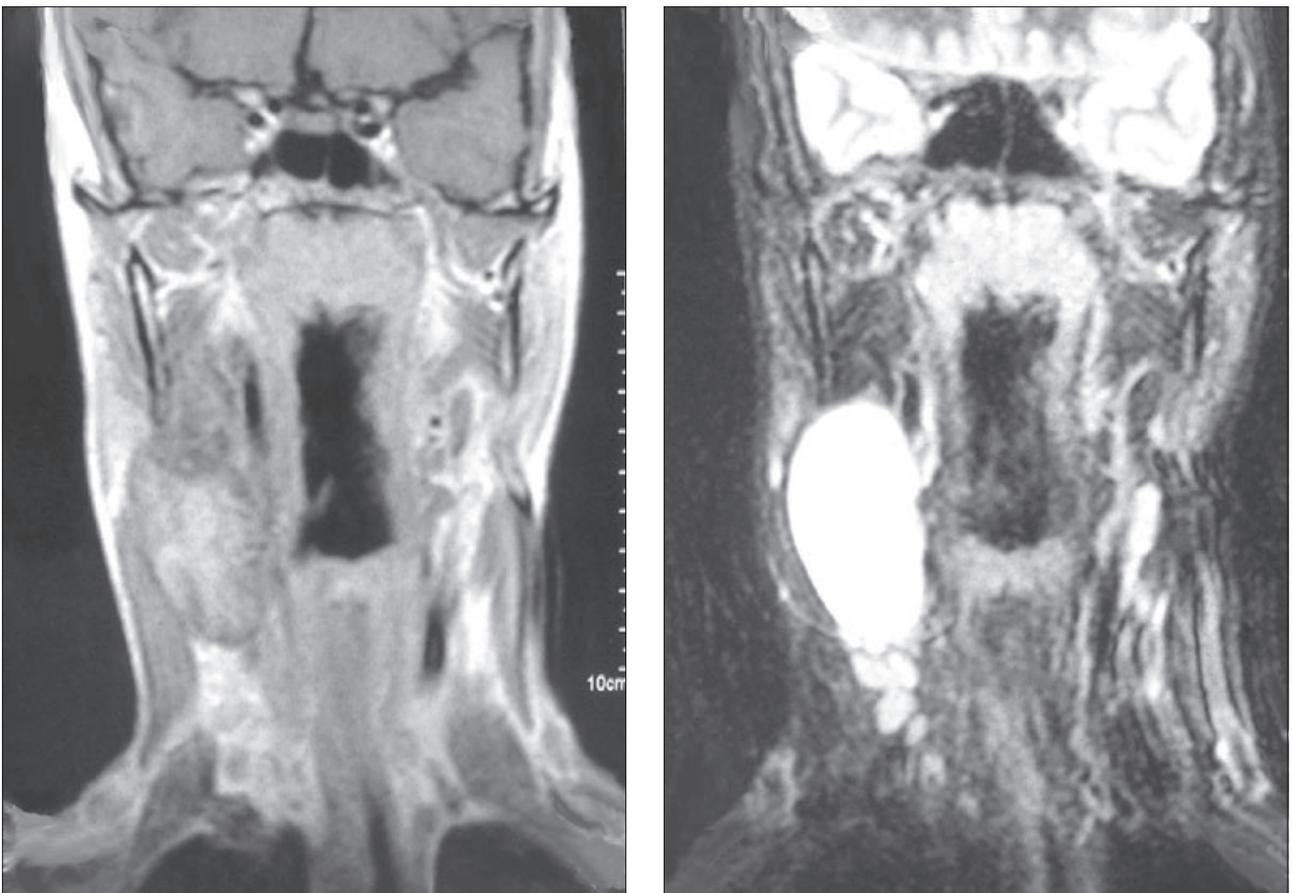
Sagittal view of the patient's MRI scan, showing location of the tumor.
